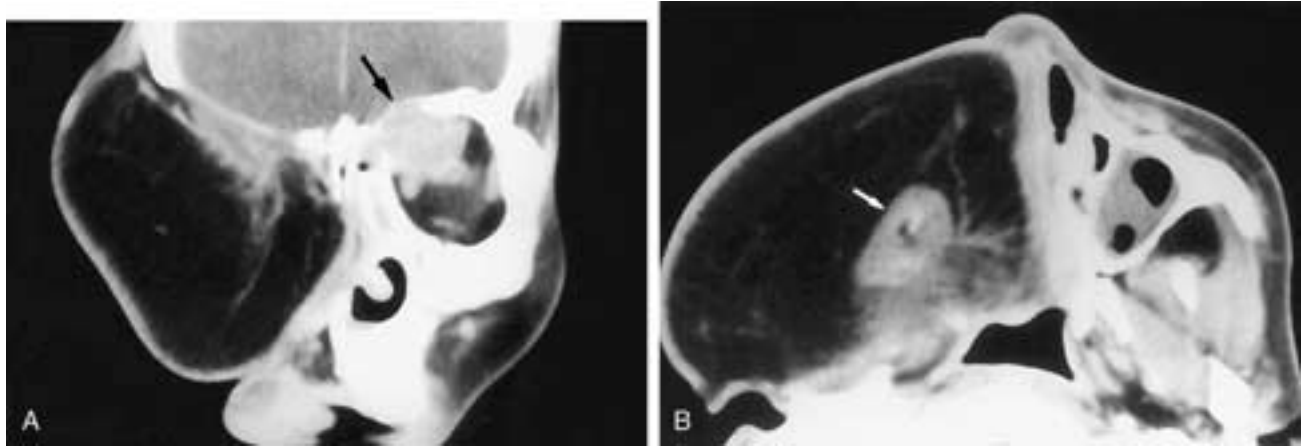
Coronal (A) and axial (B) CT scans on a patient who has had multiple recurrences of a rhabdomyosarcoma after chemotherapy, irradiation, and numerous operations. Finally, a large myocutaneous graft was used to replace her entire right facial region. The bulk of this graft makes clinical detection of a recurrence within it extremely difficult. Imaging shows the muscle (arrow in B) within the graft and no evidence of tumor recurrence. However, tumor has now recurred on the left side of the craniofacial graft and in the upper left orbit (large arrow in A).
